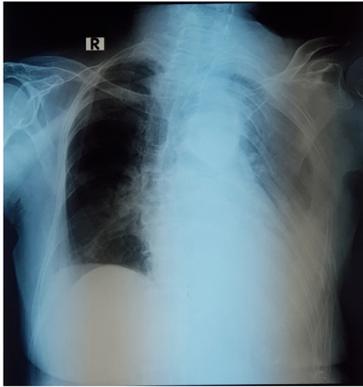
Thorax X-ray showed massive opacity the multiple rib fractures on the left chest
